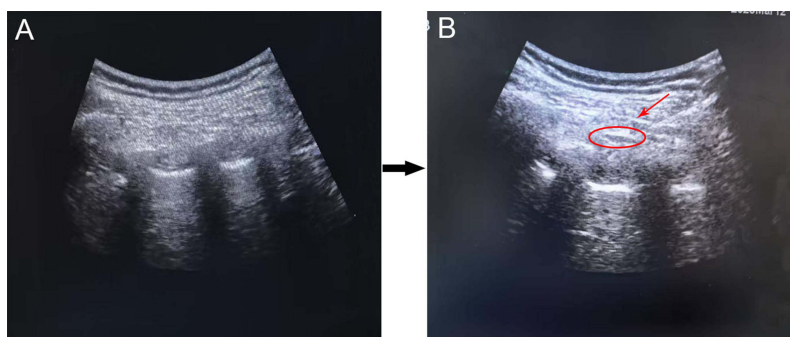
(A) Ultrasonography image of chest wall before ICNB. (B) Needle trajectory (red arrow) and drug spread in the intercostal space (Red circle).
